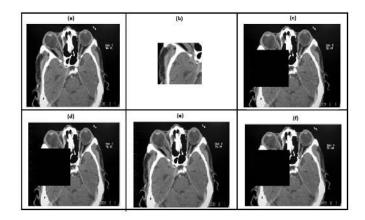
(a) The original host MRI image, (b)ROI image of host image,(c)Roi removed image (c)Emebedded image without ROI, (d)Final embedded image with ROI
